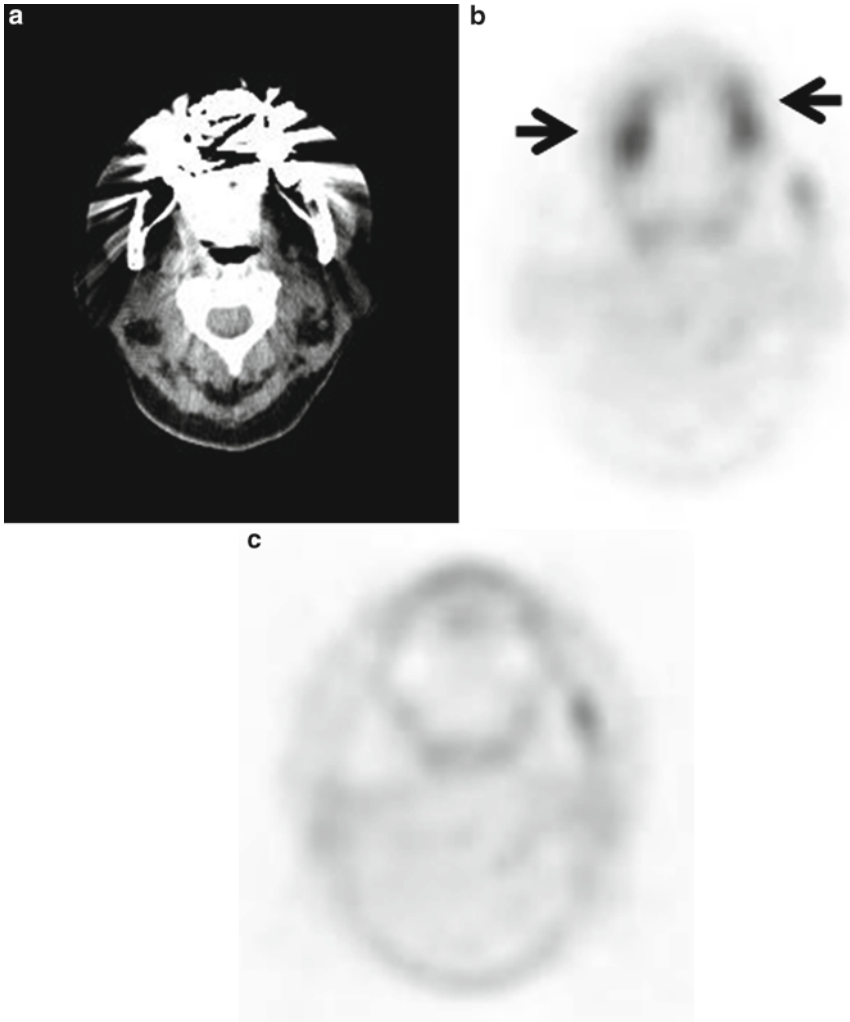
High-density metallic implants generate streaking artifacts and high CT numbers on CT image. High CT numbers will then be mapped to high PET attenuation
